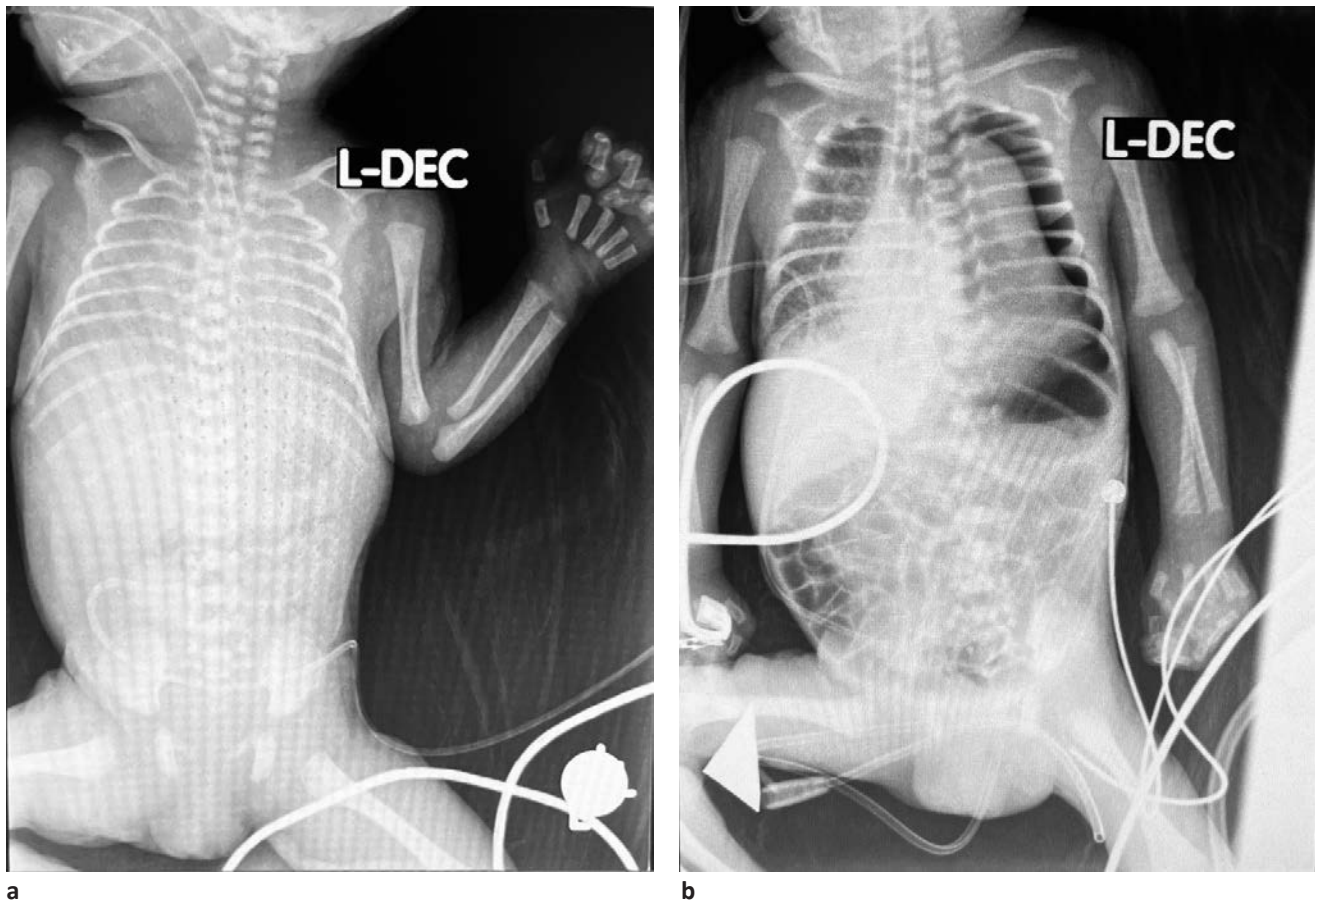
Thoracoabdominal radiography. a: after admission; b: 6 days of life
